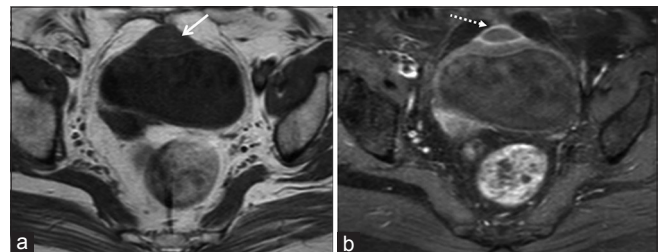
Axial T1-weighted magnetic resonance image showing a low-signal intensity intramural solid cystic lesion (thick white arrow), with focal apico-anterior bladder wall thickening (a). Axial contrast-enhanced magnetic resonance image showing peripheral rim enhancement in the central T2 hyperintense cystic component (dotted white arrow), with a hypoenhancing central core (b)
